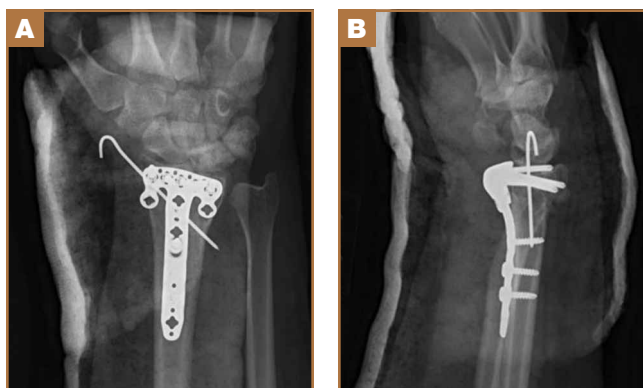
Postoperative (A) anteroposterior and (B) lateral radiographs of right wrist.
